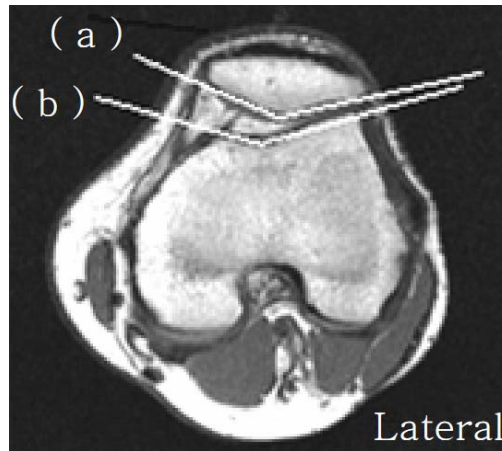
MRI transverse view at the mid patellar level while the knee extended.
